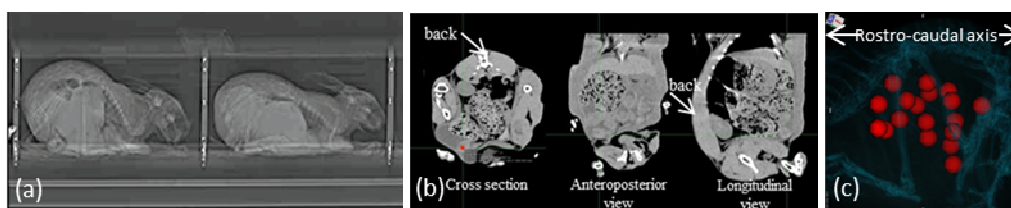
X-ray radiography of does: overall view (a), and slices (b); 3D view of the embryonic vesicles reconstituted by image analysis (c)
